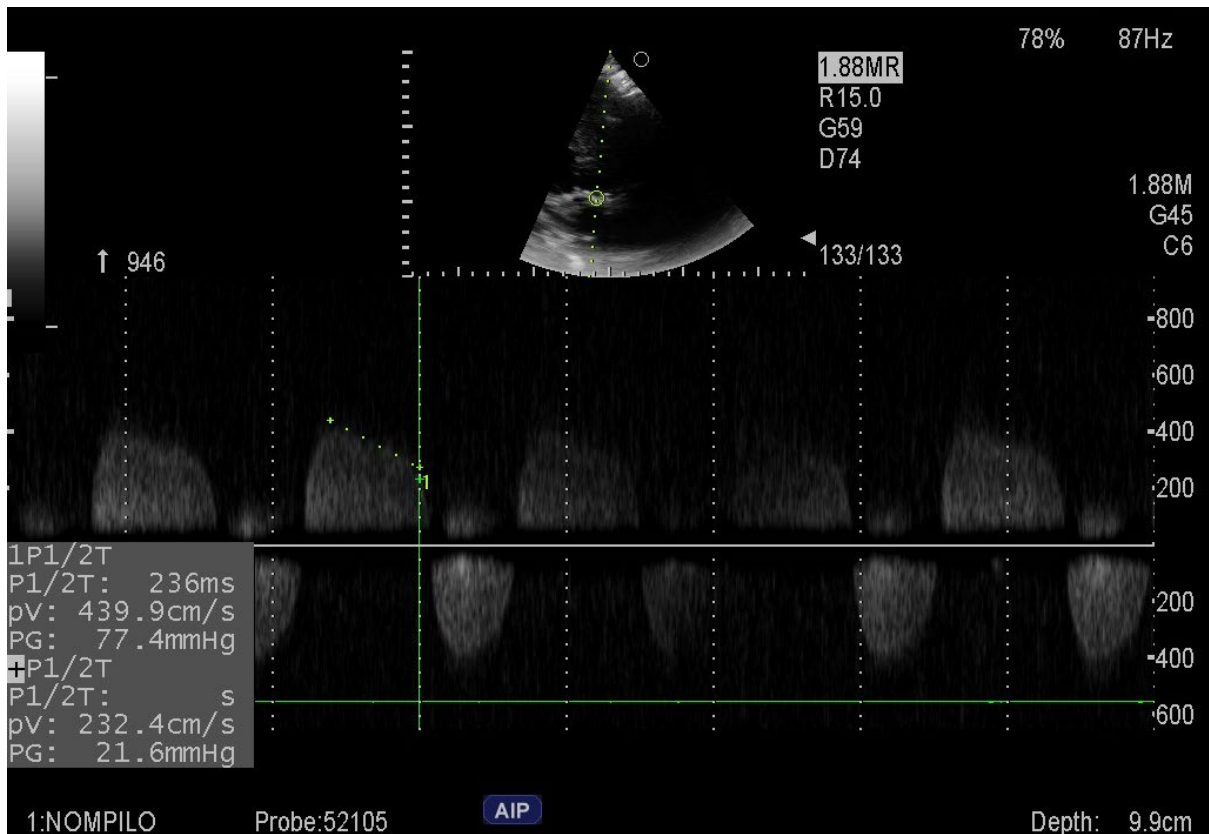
Measurement of PHT is apical five chamber view.
